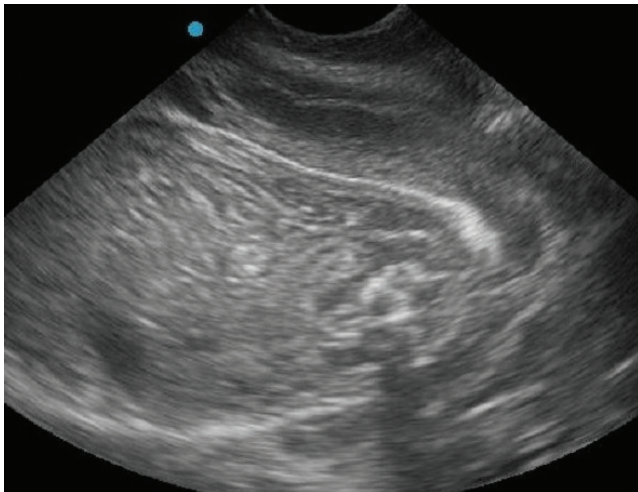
Transabdominal ultrasound image of a fetal gastrointestinal tract, note the architectural detail indicating progression of fetal maturity.
